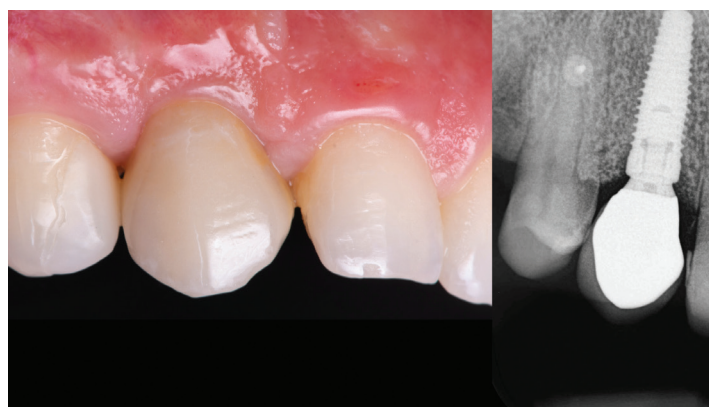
Clinical (left) and radiographic (right) view at 6-year post-loading follow-up.
